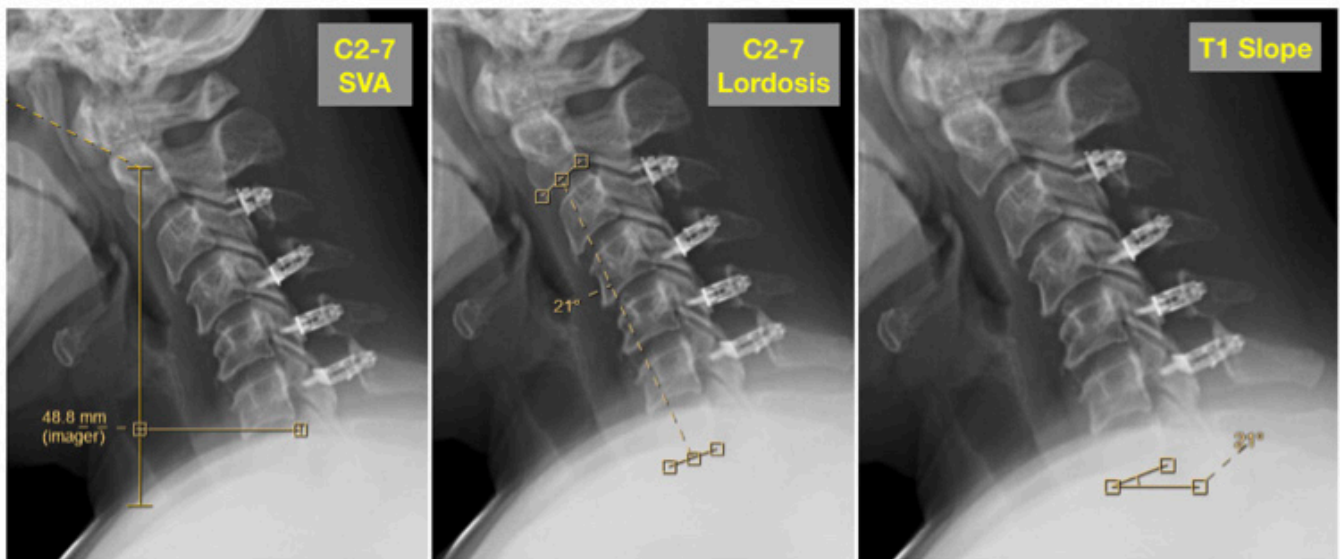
Representative cervical alignment radiographic parameters. SVA, sagittal vertical axis.
